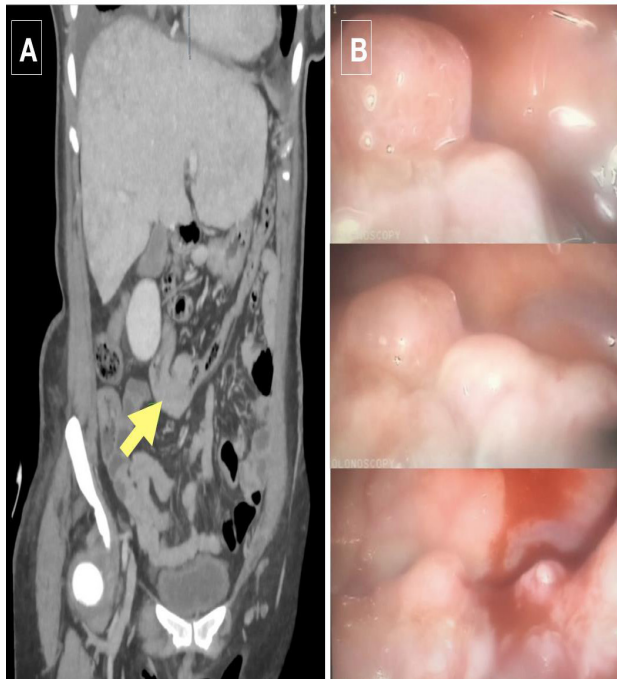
(A) Coronal view of abdominal CT scan showing circumferential wall thickening in proximal transverse colon (yellow arrow). (B) Colonoscopy Findings at the level of transverse colon showing presence of a polyloid friable lesion with minimal bleeding after biopsy.
